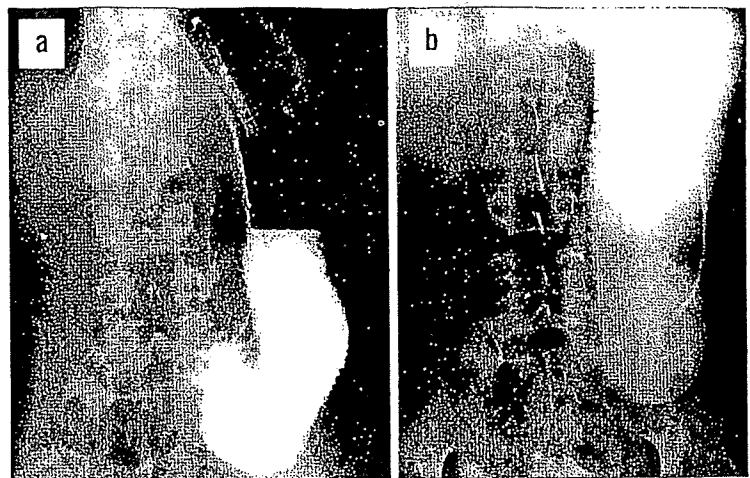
Radiograph of the jejunal pouch on admission showing (a) immediately after the intake of water-soluble contrast medium, and (b) 150 minutes later.
